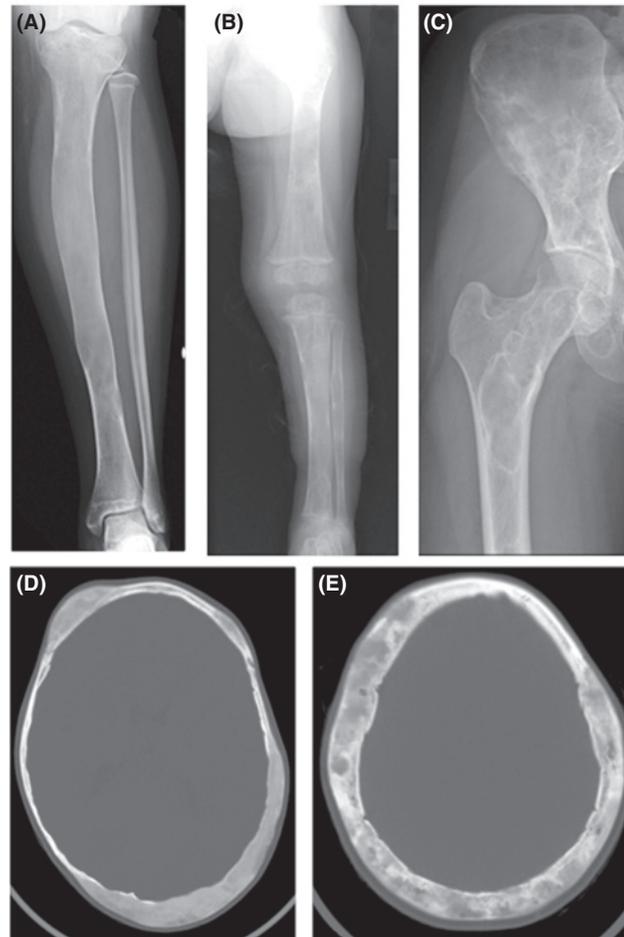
Radiographic appearance of FD. The classic description of the radiographic appearance of FD is “ground glass,” which is depicted in the tibia (A). In very young children, the appearance has more of a streaked appearance (B), and in older patients with less active disease there is often a sclerotic rim around FD lesions (C). On CT scanning in young children the appearance is, again, homogeneous and ground glass (D), but with age, the appearance is inhomogeneous and mottled, and is sometimes reported to be “cystic” (E).
